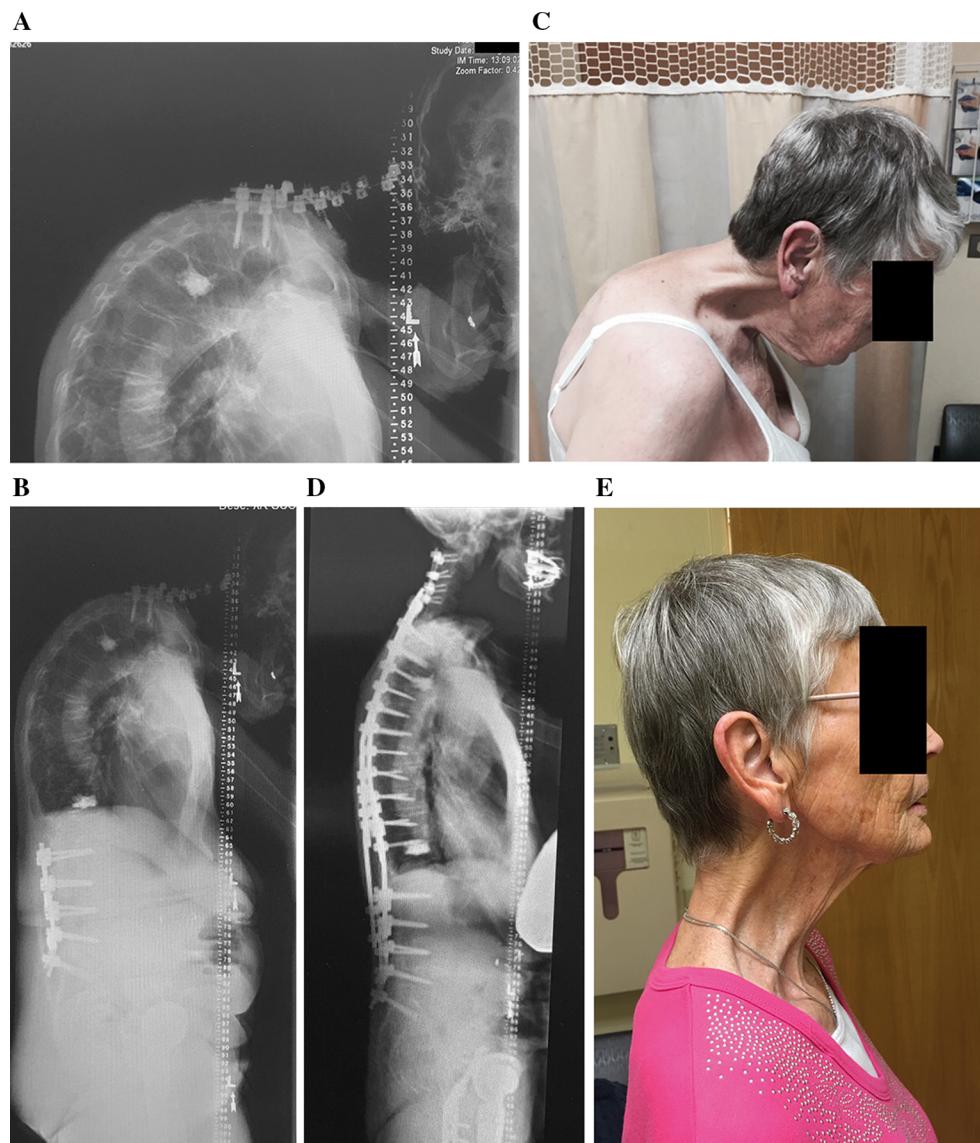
Case example of 68-year-old woman treated with a three-column osteotomy for chin-on-chest cervical deformity. This patient provided consent for publication of her images. Shown are lateral cervical (a) and full-length lateral (b) standing radiographs that demonstrate prior cervicothoracic and lumbo-sacral instrumented
